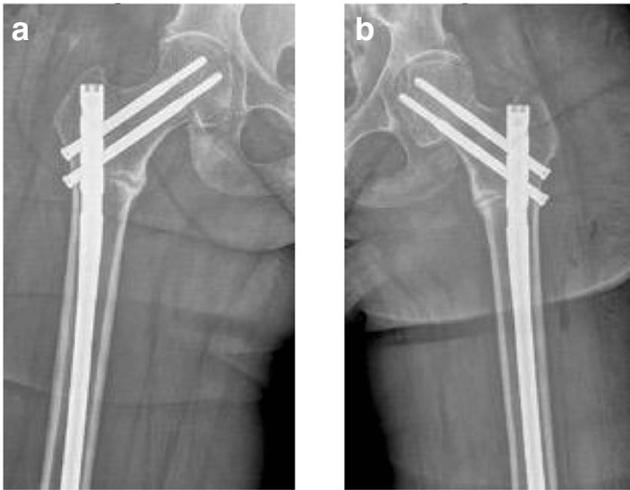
a, b The AP postoperative radiographs at 2.5 weeks
